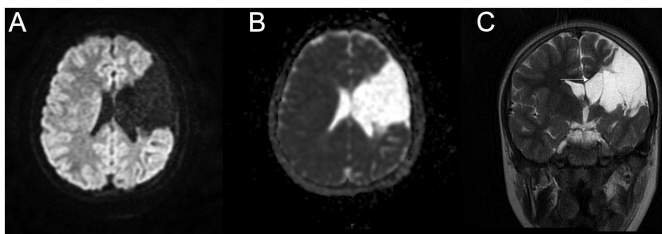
A large porencephalic cyst was detected in the frontotemporal region in diffusion-weighted MR images and ADC map of a 21-year-old man (A, B). Encephalic volume loss in left frontotemporal lobes evidenced by hydrocephalus ex vacuo (C) (arrow). ADC, apparent diffusion coefficient; MR, magnetic resonance.
